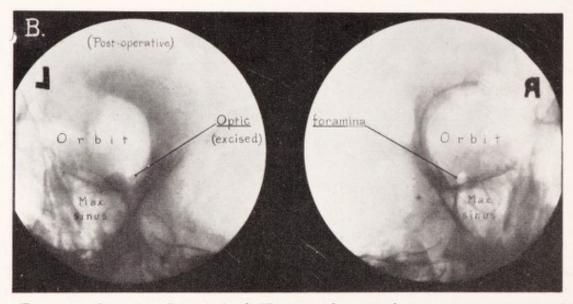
Case 3. Retouched X-rays of optic foramen on tumor side and on normal side: (A) before operation; (B) after operation. Lateral wall of the foramen on the side involved by tumor was removed.
